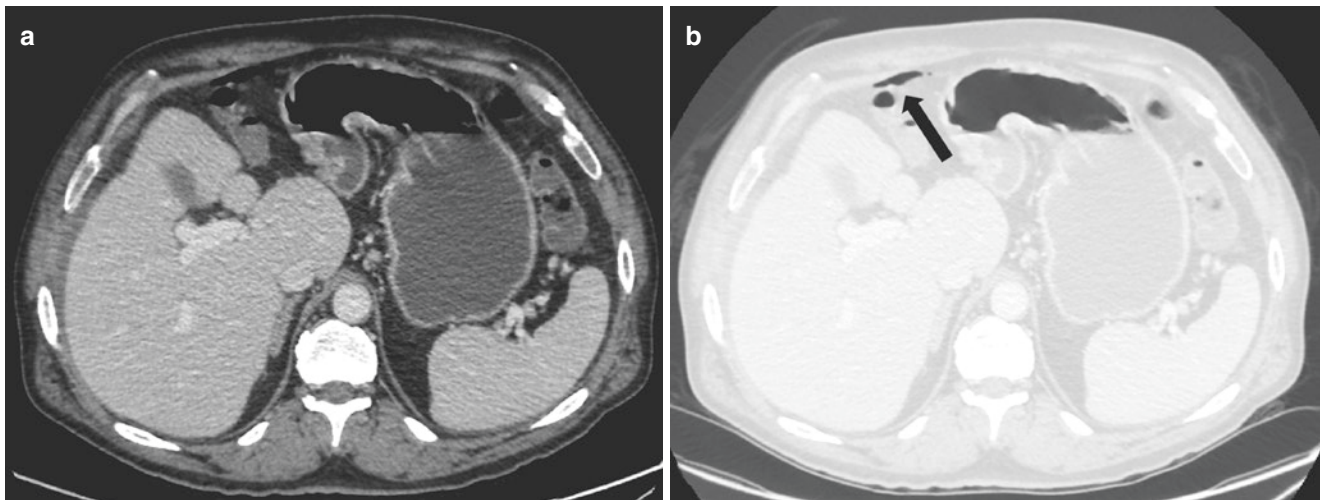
CT of a 55-year-old man with abdominal pain. On the soft tissue window (a), the free air collection may be difficult to depict, but the use of the pulmonary window (b) makes it easy to identify the air collection adjacent to the stomach (arrow)
